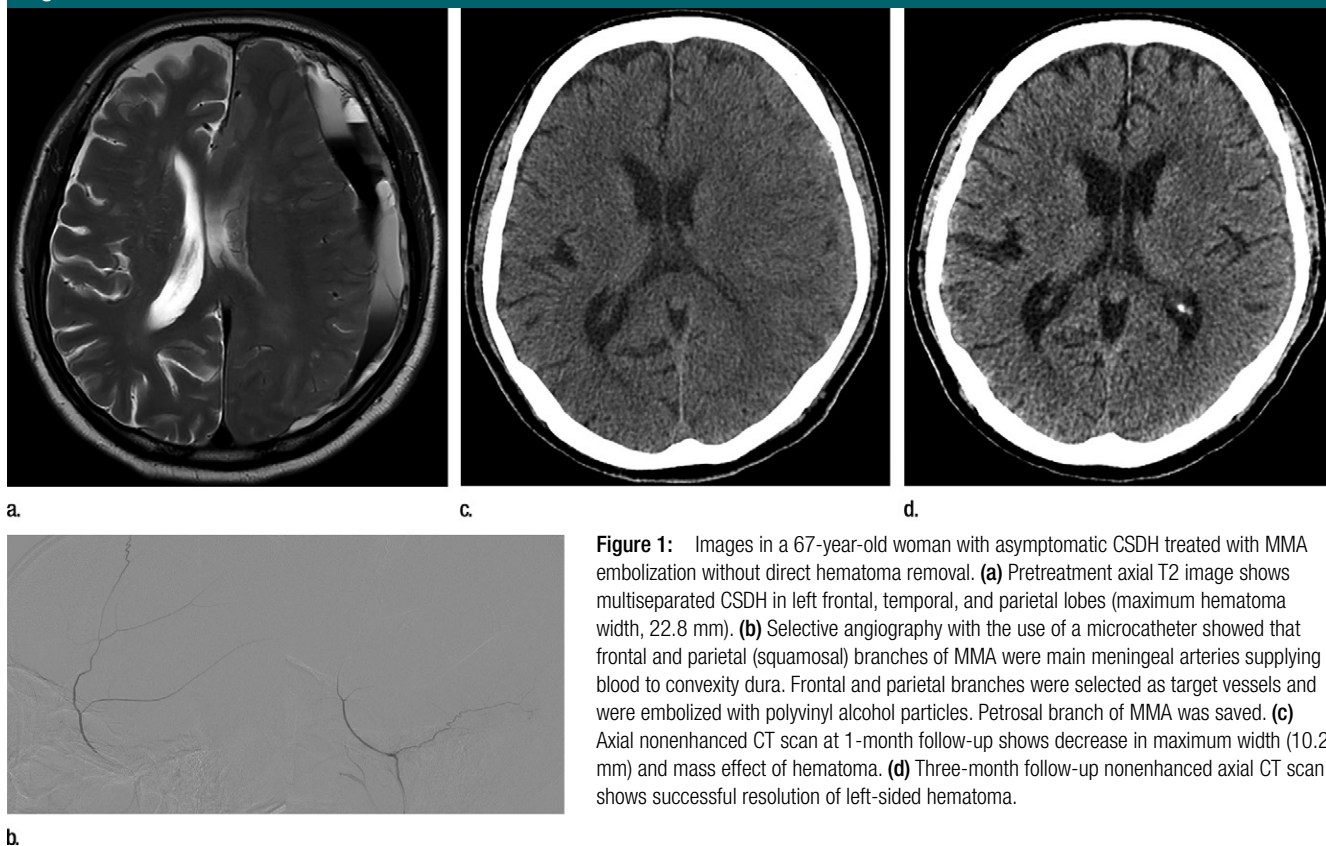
Images in a 67-year-old woman with asymptomatic CSDH treated with MMA embolization without direct hematoma removal. (a) Pretreatment axial T2 image shows multiseptated CSDH in left frontal, temporal, and parietal lobes (maximum hematoma width, 22.8 mm). (b) Selective angiography with the use of a microcatheter showed that frontal and parietal (squamosal) branches of MMA were main meningeal arteries supplying blood to convexity dura. Frontal and parietal branches were selected as target vessels and were embolized with polyvinyl alcohol particles. Petrosal branch of MMA was saved. (c) Axial nonenhanced CT scan at 1-month follow-up shows decrease in maximum width (10.2 mm) and mass effect of hematoma. (d) Three-month follow-up nonenhanced axial CT scan shows successful resolution of left-sided hematoma.
